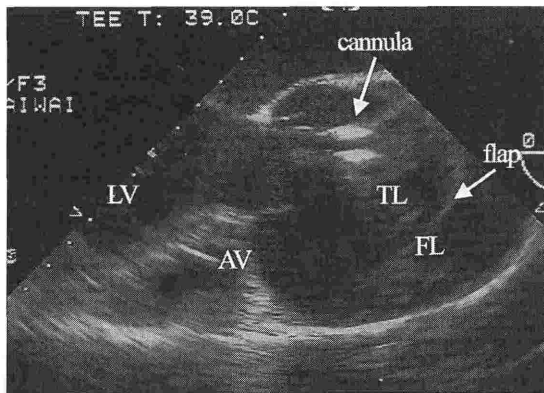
The tip of cannula was at the level of Valsalva's sinus monitored by transesophageal echocardiography.
